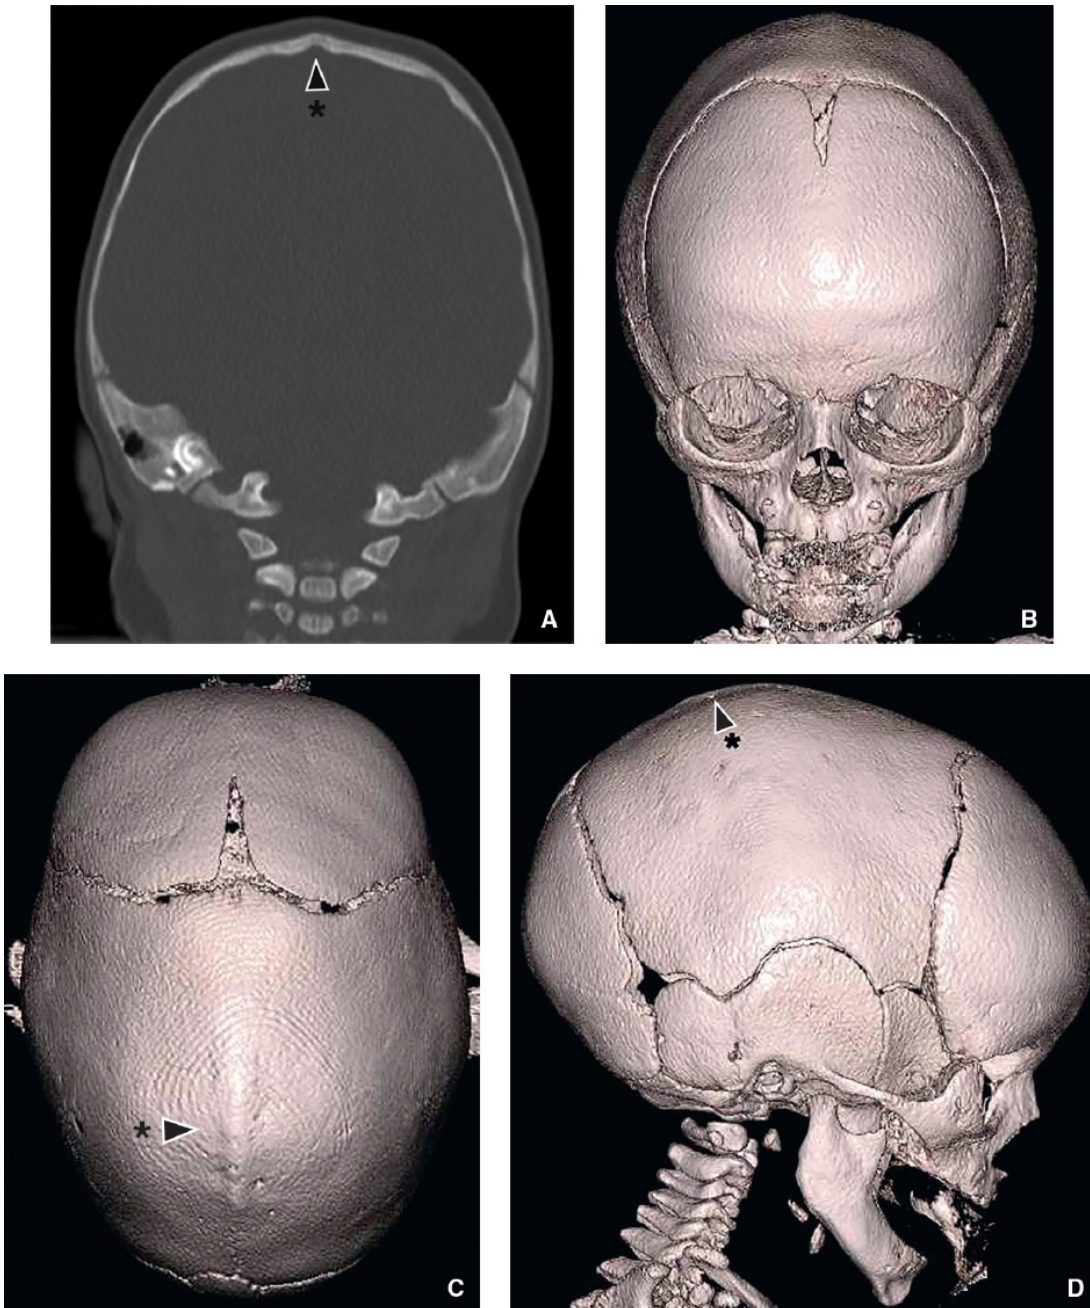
Sagittal synostosis in a 3-month-old boy with dolichocephaly and midline osseous ridging. A: Coronal reformatted bone window CT image shows premature fusion of the sagittal suture accompanied by osseous ridging (*asterisked black arrowhead*). B–D: Frontal (B), superior (C), and right lateral (D) surface rendering CT images confirm the osseous ridging and depict the elongated AP dimension of the skull consistent with clinical impression of dolichocephaly. When accompanied by osseous ridging, dolichocephaly is called scaphocephaly, a characteristic appearance for sagittal synostosis. Note that the metopic suture has already undergone fusion without deformity, consistent with normal closure.
